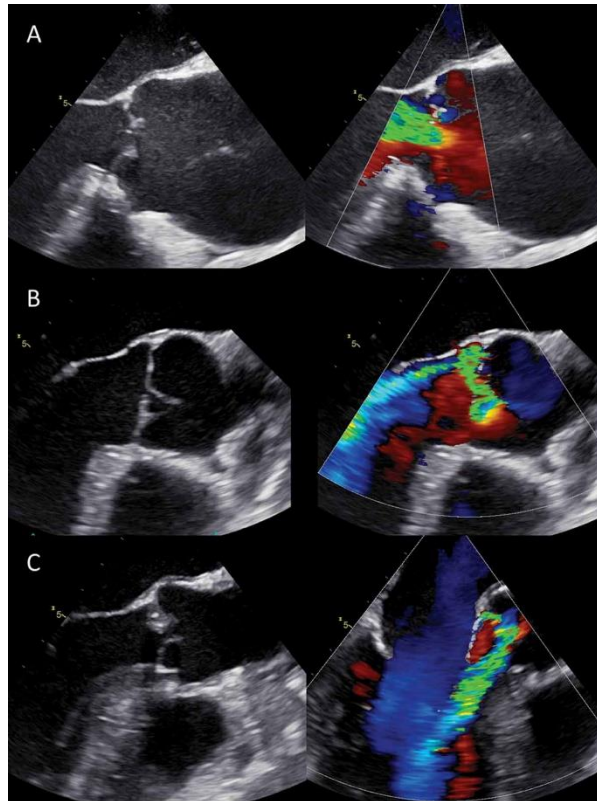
Mechanisms of aortic regurgitation as assessed with transesophageal echocardiography. Mid-esophageal long-axis view of the aortic valve. (A) Aortic regurgitation type 1 due to aortic root dilation. (B) Aortic regurgitation type 2 due to leaflet prolapse. (C) Aortic regurgitation type 3 due to cusp restriction.
